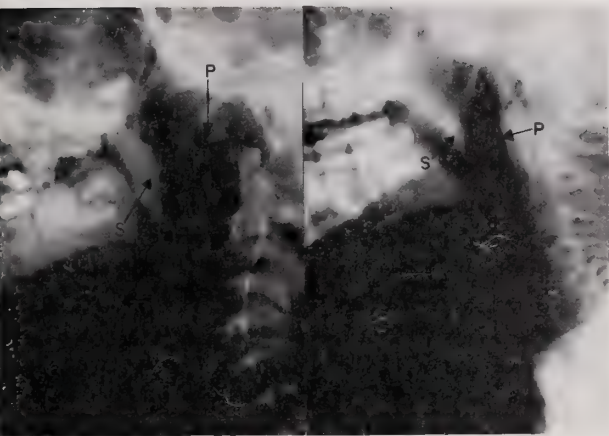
Radiographic examination of the nasopharynx in the evaluation of velopharyngeal incompetence necessitates lateral neck x-rays, a technique available in most radiology departments. A, (left) shows a normal subject producing the test sound Mm. The soft palate (s) is anterior to the pharyngeal wall (P) creating a wide nasopharyngeal isthmus. B, our patient with velopharyngeal incompetence demonstrates the same normal relationships while phonating Mm. However, the palate is short and cannot touch the posterior pharyngeal wall as the adenoid has been removed.
